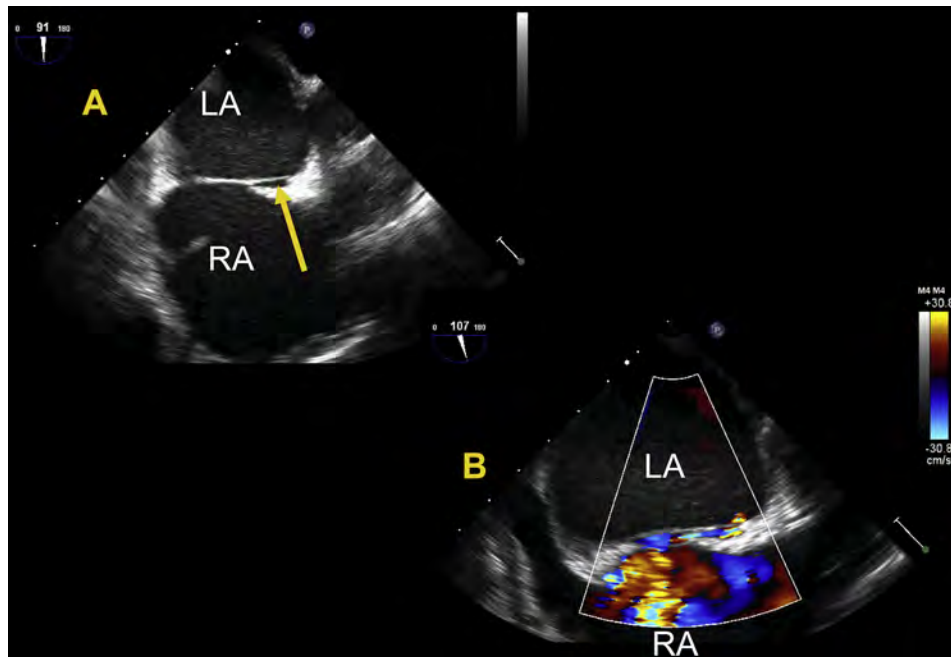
Two-dimensional TEE of a PFO (yellow arrow) in bicaval views (A) without and (B) with color Doppler in an adult patient.
